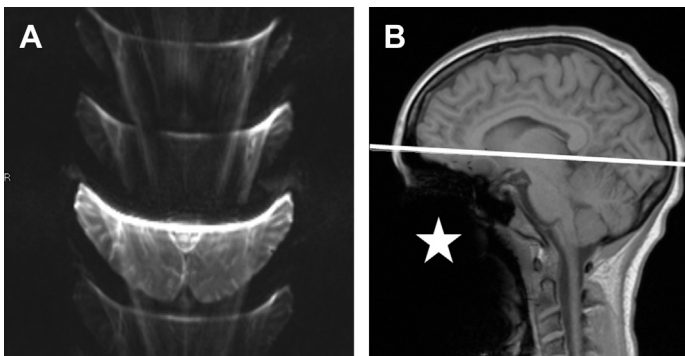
Prominent susceptibility artifact is seen on DWI image (A), caused by orthodontic appliance in a young patient. Sagittal T1 (B) shows the angulation of the axial DWI (white line) and a large area of signal void overlying the oral cavity and facial tissue (asterisk), also caused by susceptibility for magnetic field changes. The DWI artifact might be reduced if the slices are aligned more parallel with the frontal skull base.
